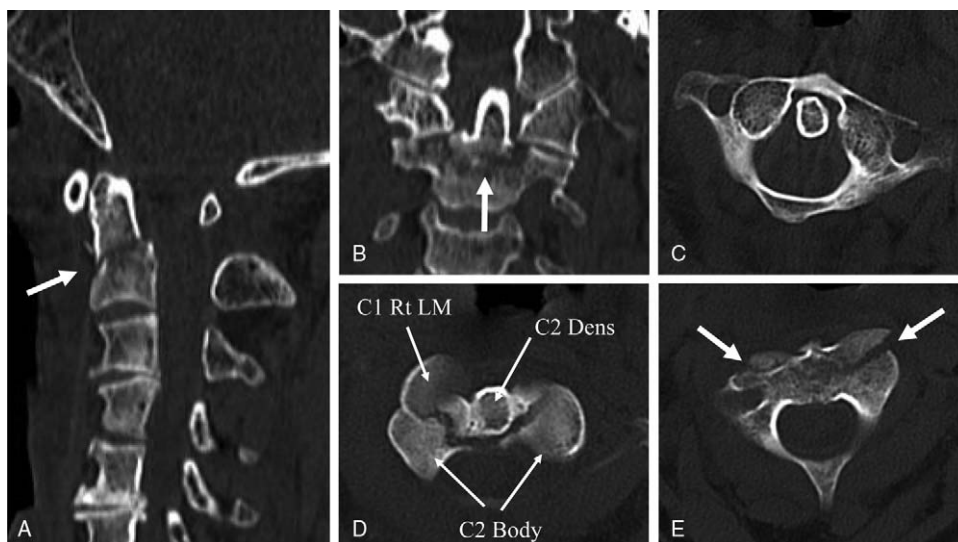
Two-dimensional reconstructed CT scans demonstrated a type III dens fracture that was established based on the Anderson and D'Alonzo classification (white arrow) (A and B), type 2 traumatic C1–2 rotatory subluxation that was established based on the Fielding and Hawkins classification (C and D), and bilateral articular facet fractures of C2 (white arrows) (E). However, the atlantodental interval (ADI) was normal. CT=computed tomography.
